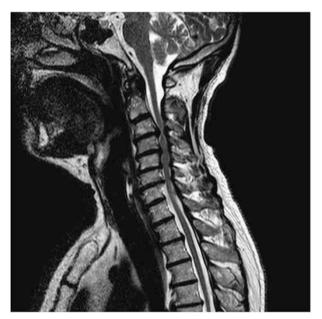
MRI spine showing severe degenerative change between C3/4 and C6/7 with compression of the cord (cervical spondylosis with myelopathy).
